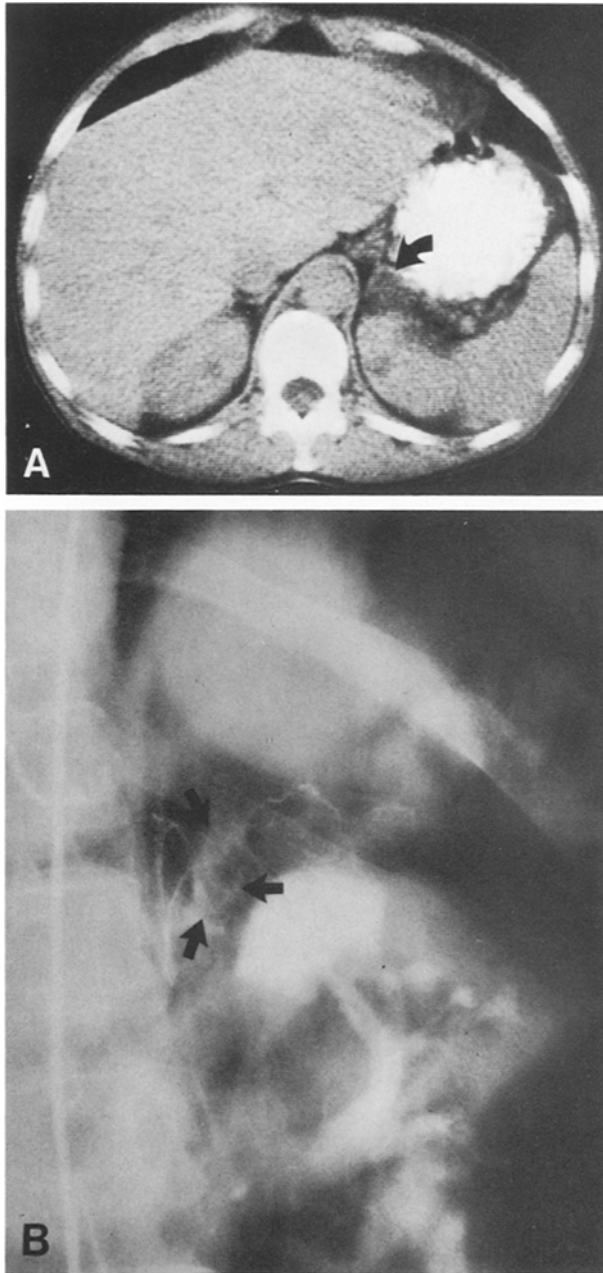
A CT scan left adrenal enlargement (A) was reinforced by arteriography (B) in a hypertensive patient thought to have symptoms of pheochromocytoma, but without biochemical confirmation. Adrenalectomy of a normal left adrenal left the patient unimproved.
